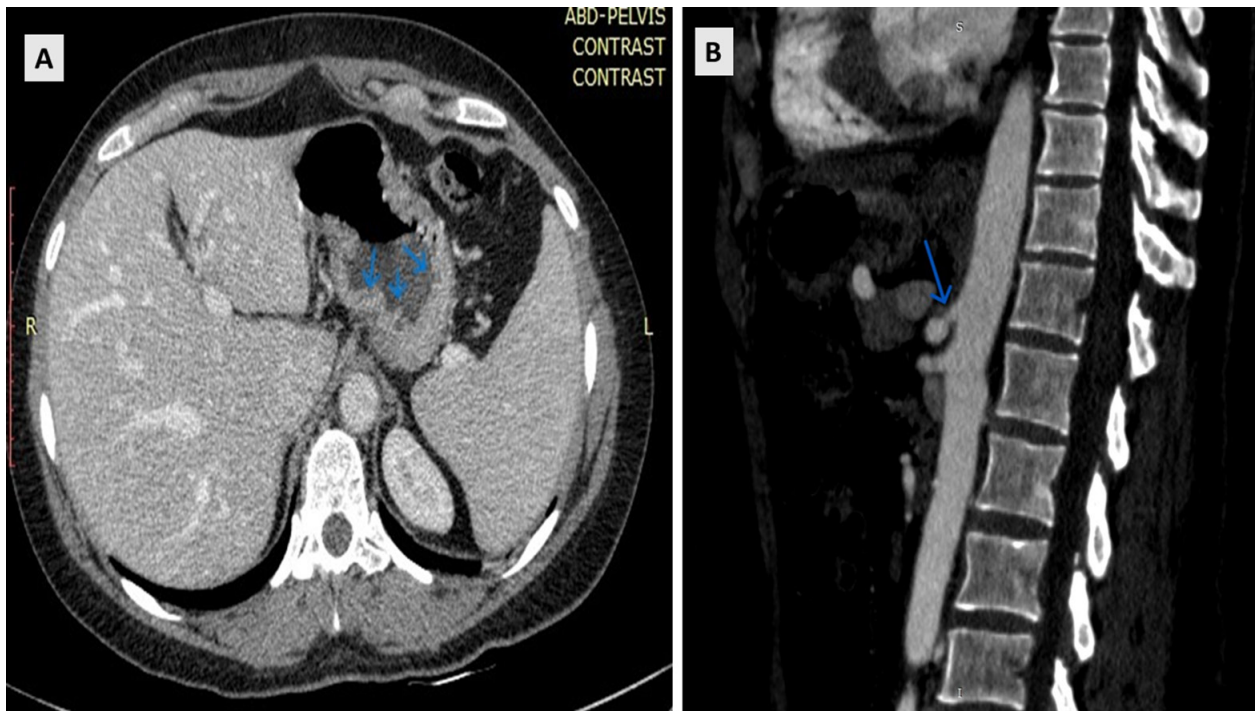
(A) Axial contrast-enhanced CT image demonstrates notable circumferential wall thickening of the gastric body (blue arrows). (B) Sagittal reformatted image shows narrowing of the celiac artery by extrinsic compression by the median arcuate ligament (blue arrow).
